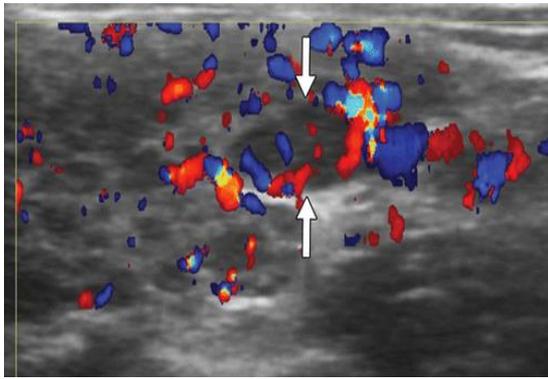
35 year old woman showing colour Doppler flow within the 2cm solid nodule in lower pole of left thyroid with parenchyma heterogeneity.
